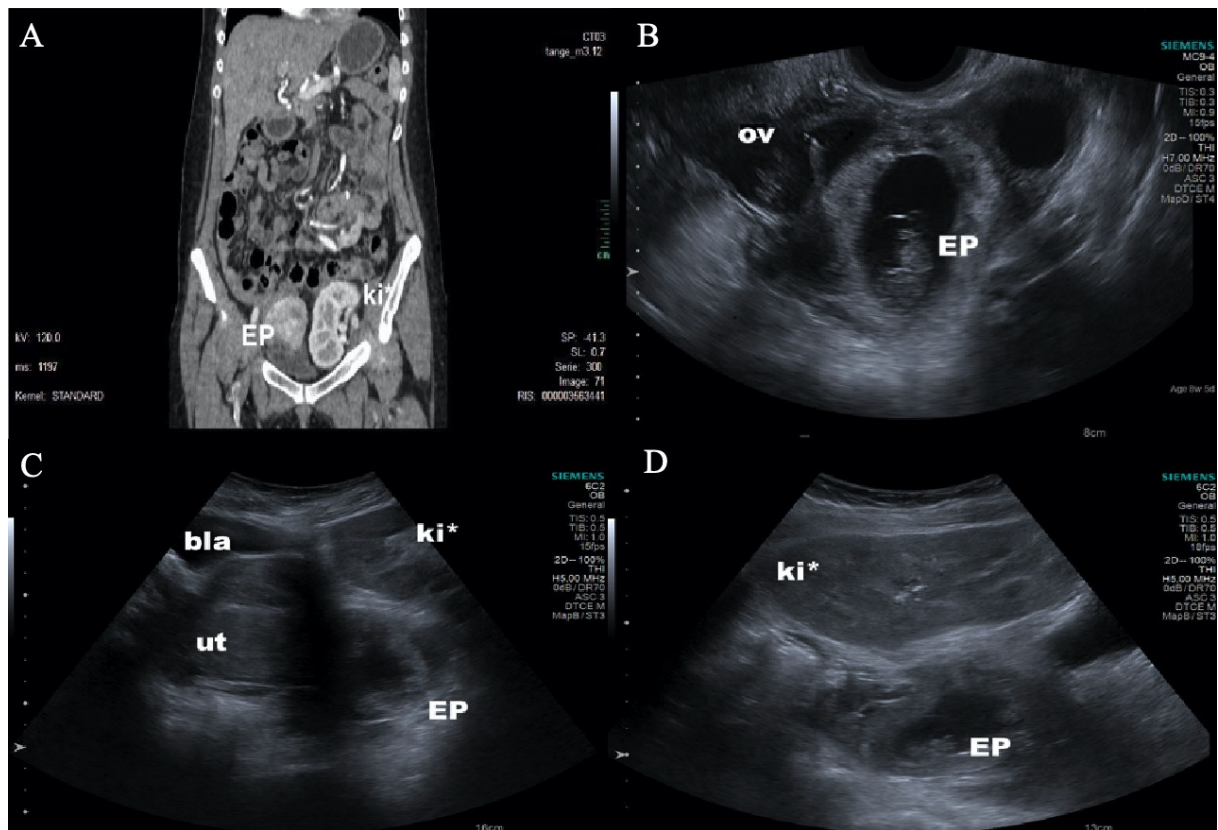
A. CT scan — frontal plane, in bottom left ectopic pregnancy (EP), in bottom right transplanted kidney (ki*); B. Transvaginal ultrasound — transverse plane, EP in the left oviduct located beside left ovary (ov); C. Transabdominal ultrasound — longitudinal plane, scan reflects the localization of transplanted kidney (ki*), EP, uterus (ut) and bladder (bla); D. Transabdominal ultrasound — transverse plane, transplanted kidney (ki*) and EP in the left lower abdomen.
